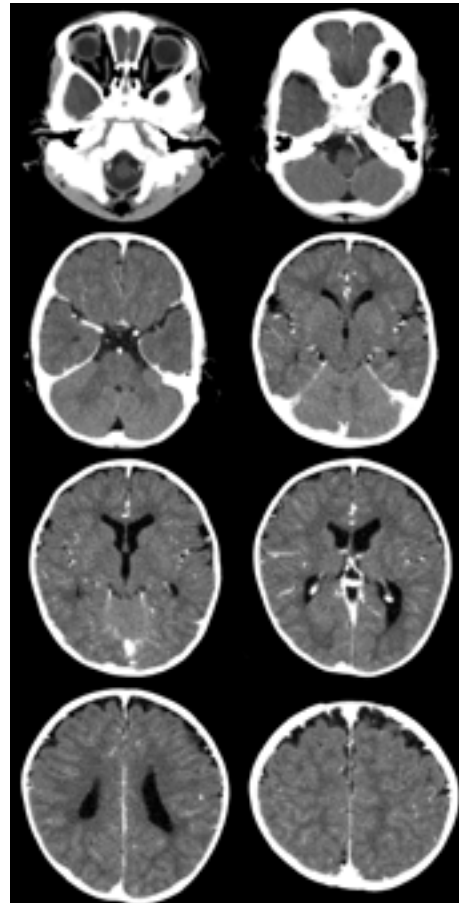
Low X-ray dose pediatric brain scan of 11 month old with Brilliance CT 64-channel scanner equipped with Essence technology.
